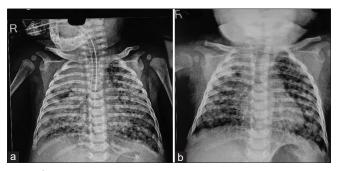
(a) Initial chest X-ray (first admission) showing bilateral miliary infiltrates, and right upper lobar consolidation. (b) Chest X-ray (current admission) showing persistence of radiological findings
